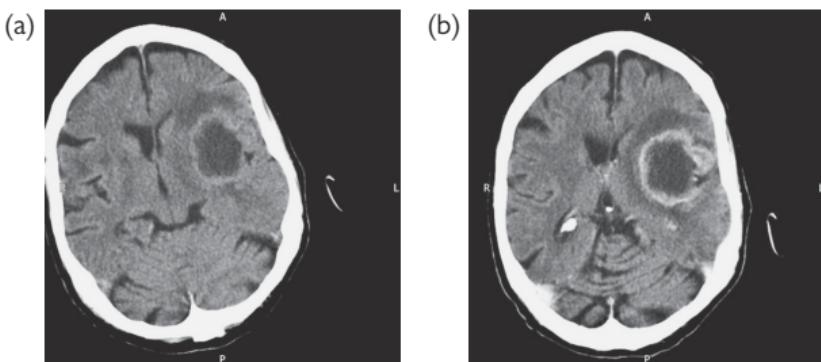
CT showing cerebral metastasis from a lung primary (a), 'ring-enhancing' with contrast (b).
